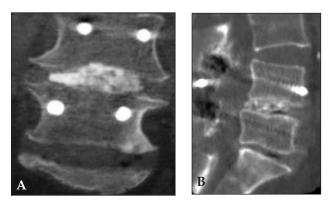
IImages with coronal (A) and sagittal (B) reconstructions of the lumbar spine with fine-cut bone-window CT.
